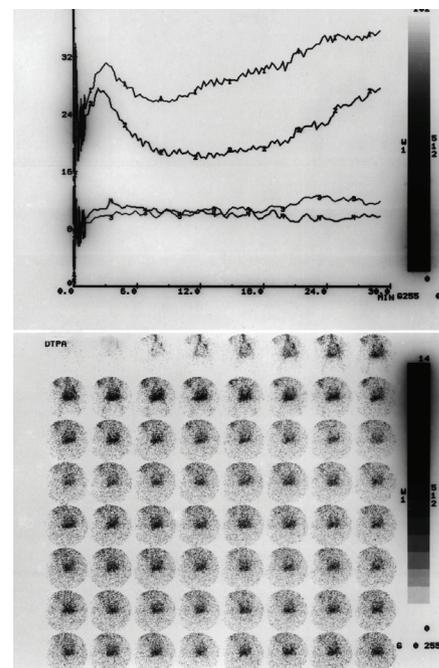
Tc-99m DTPA scintigraphy shows normal perfusion, concentration and excretion pattern in the pelvic kidney. A reaccumulation pattern was detected after 10th minute, revealing the possibility of vesicoureteral reflux.
